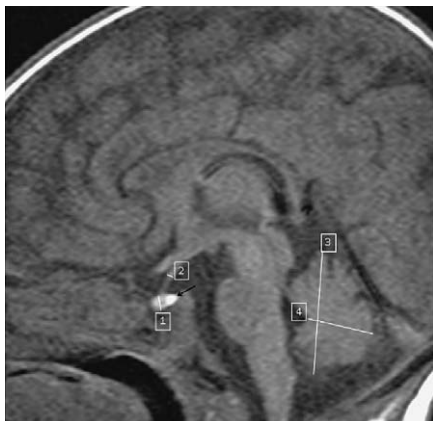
Measurement of the height of the pituitary gland (1), the expected high signal intensity of neurohypophysis (black arrow), AP thickness of the infundibulum (2), height (3) and AP width (4) of the cerebellum in the mid-sagittal plane on MRI.
